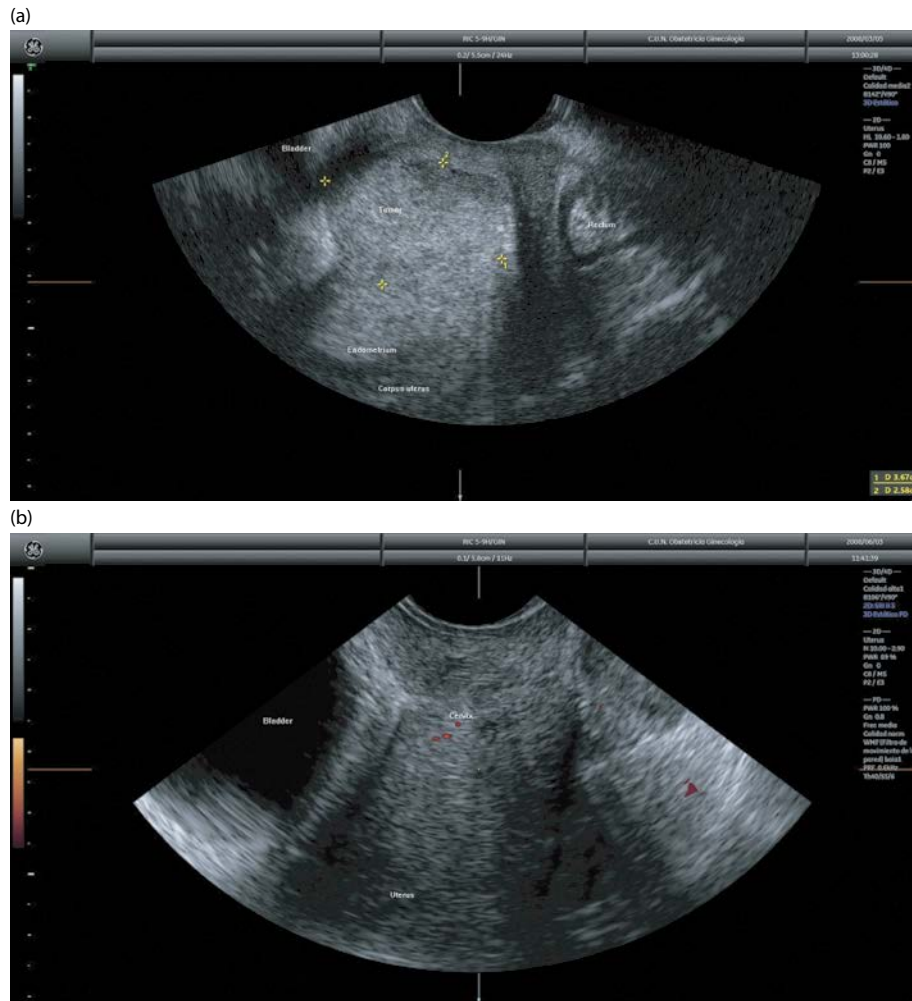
Transvaginal ultrasound in a case of cervical cancer, prior to chemoradiation (a). We can observe how the tumor disappeared after treatment (b).
